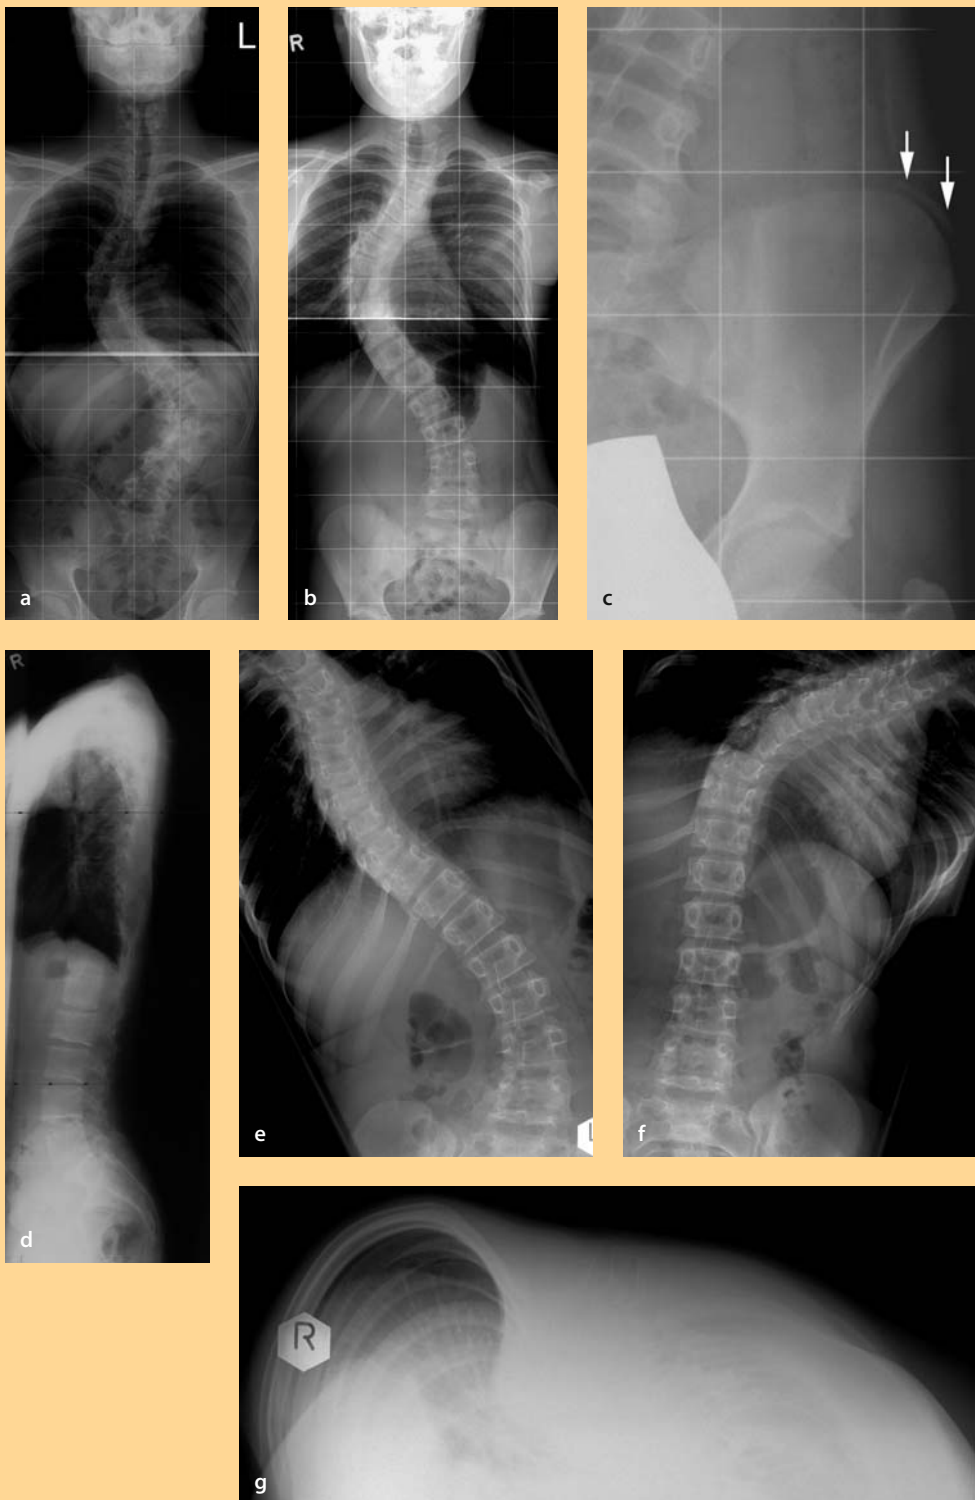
Standard radiography
